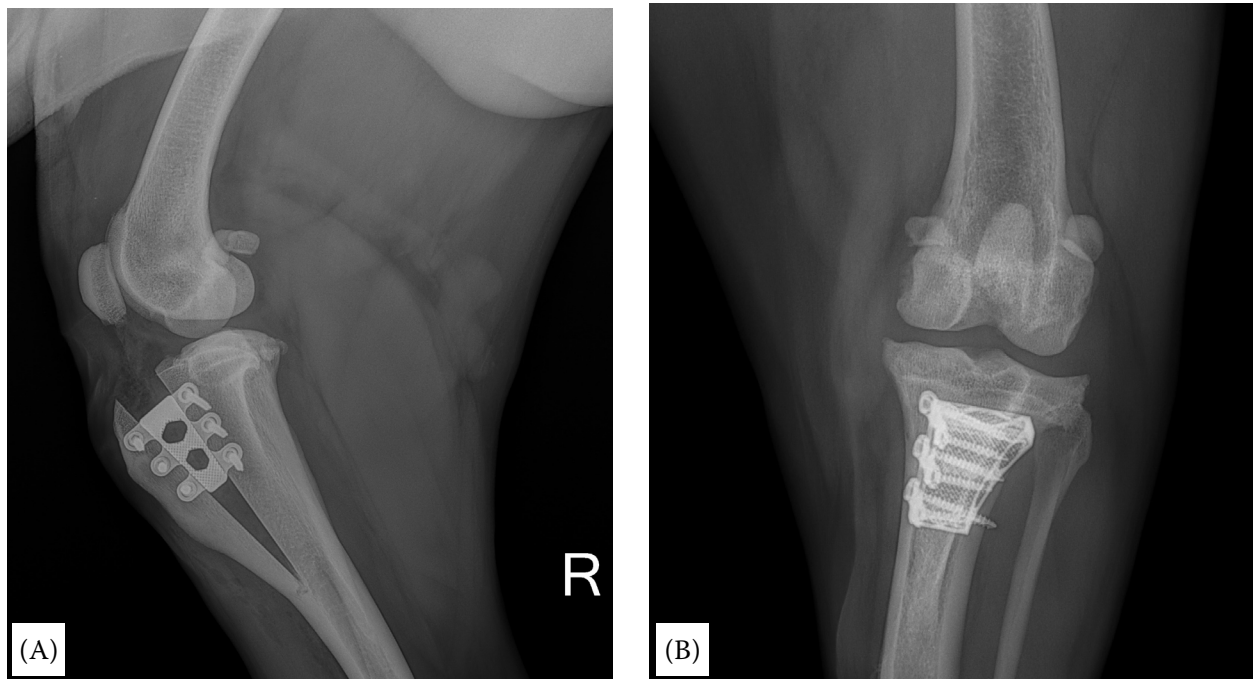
Radiographs after a TTA-rapid surgery
